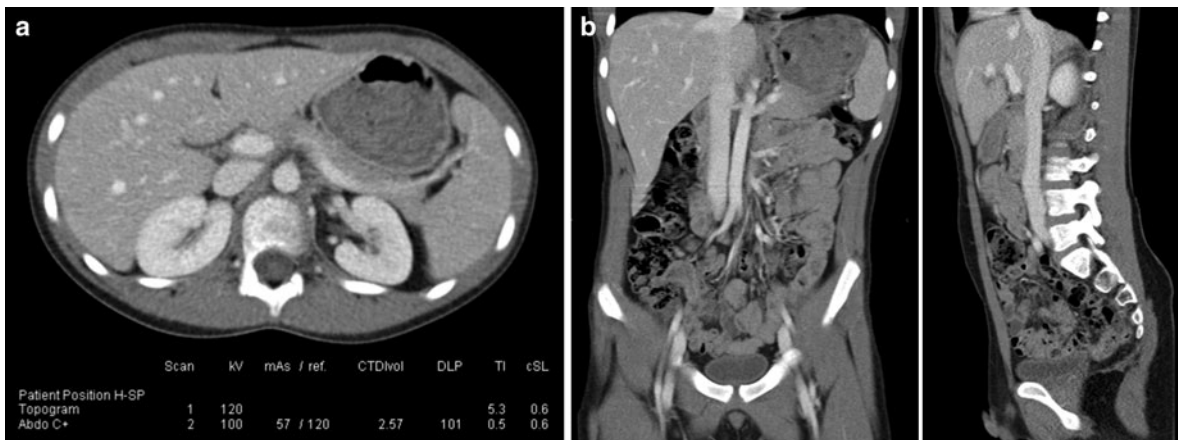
Iodine enhanced abdominal MDCT in a 12-year-old boy weighing 45 kg. No sign of appendicitis was found by CT. Low-dose protocol with U at 100 kV was chosen for
